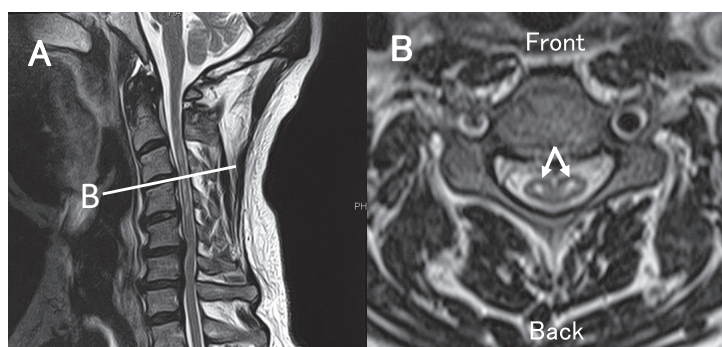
The T2-weighted cervical magnetic resonance imaging (MRI) (Admission).
